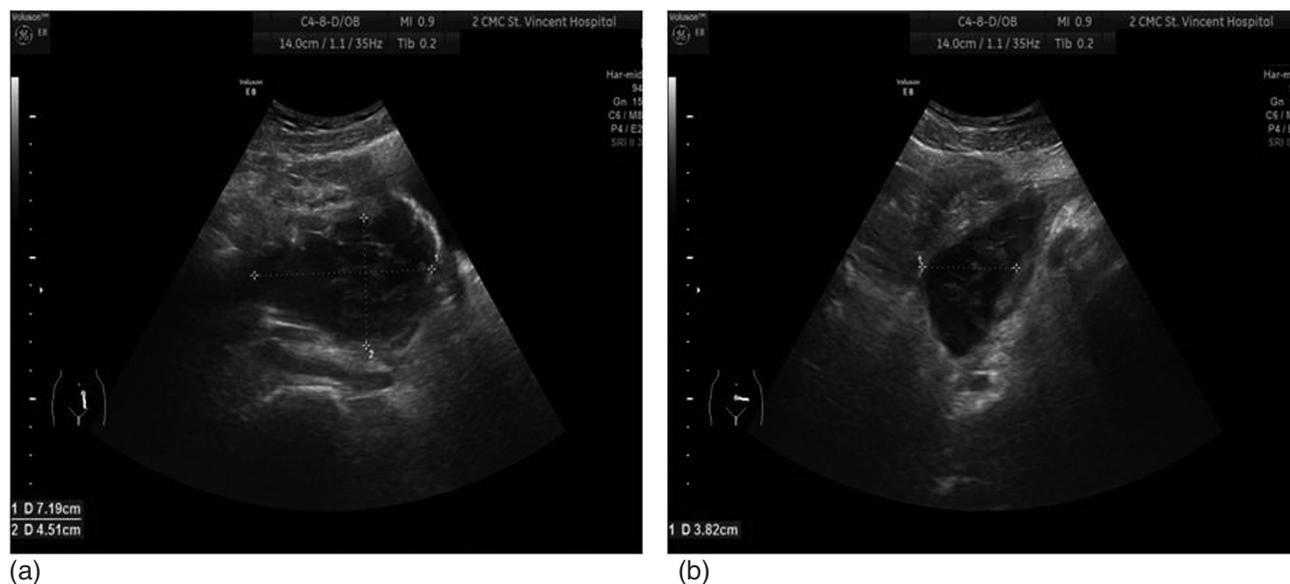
Ultrasonography visualizing the reduction in size of the hematoma to $7.1 \times 4.5 \times 3.8$ cm from the sagittal (a) and axial (b) views after insertion of the pigtail catheter.
